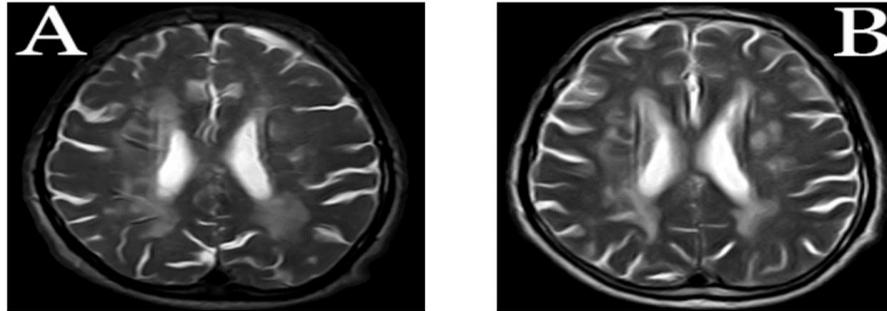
55 year old female hyperlipidemic patient presented with numbness in the left lower limb, slurred speech. T2 axial images showing Fazekas grade 3 lesions in 3 tesla MRI in A and in 1.5 tesla MRI in B.
